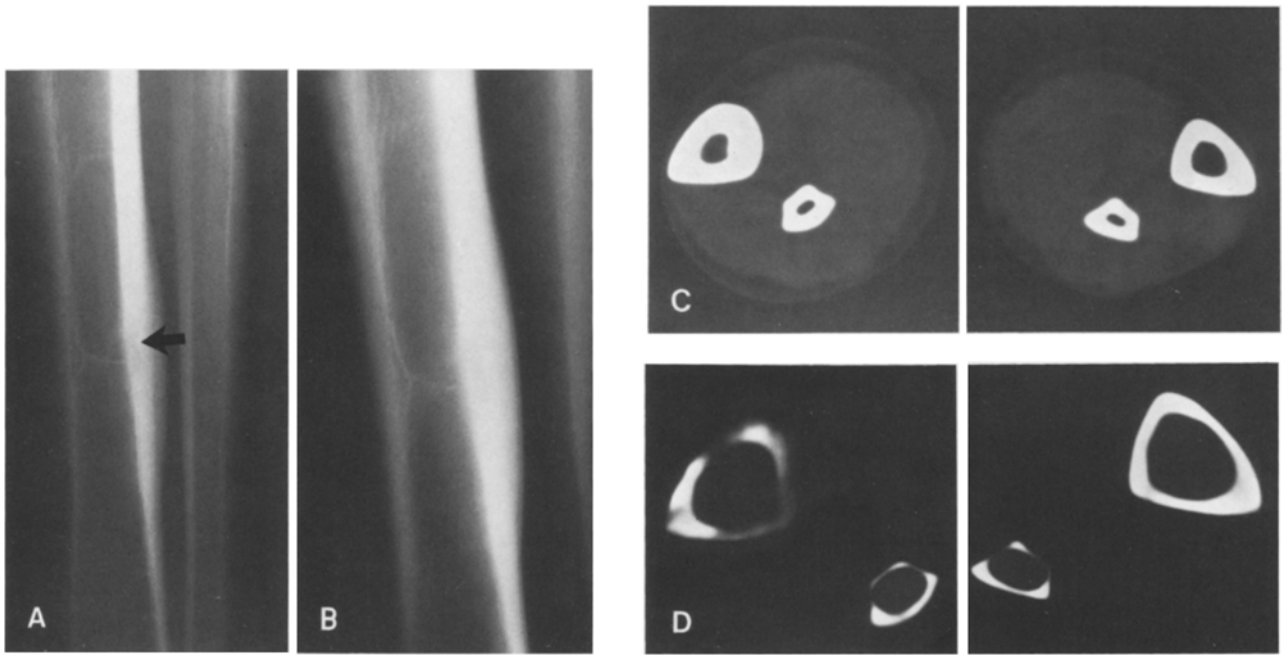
A Plain radiograph of right tibia demonstrates solid periosteal reaction and small central radiolucency (*arrow*) suspicious for a nidus. B Tomogram of right tibia demonstrates similar findings as A. No fracture lines evident. C CT shows diffuse cortical thickening of right tibia. Compare with normal left tibia. D CT scan at same area as B with “bone window” demonstrates areas of cortical thinning. Note fracture lines throughout the cortex
